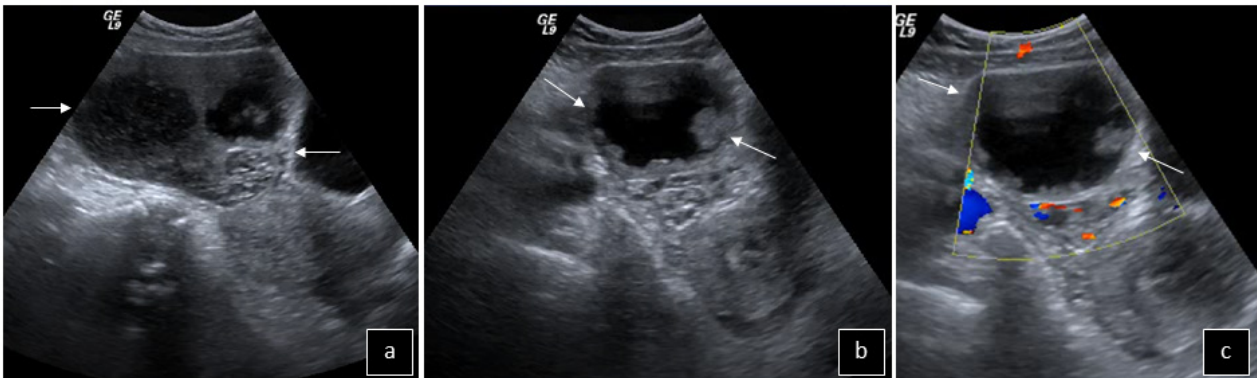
Haemorrhagic corpus luteum: A mixed echogenicity lesion (between arrows) is seen in the right iliac fossa on B-mode (a, b) and colour Doppler (c) US. It shows nodular wall and no perfusion.
